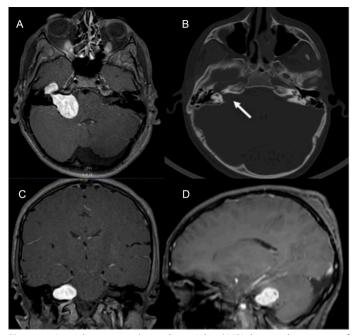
A: axial contrast-enhanced 1-weighted MRI shows enhancement of the right side mass. B: CT scan showing the tumor erosion of the right internal acoustic canal (white arrow). C and D: Coronal and sagittal MRI showing the mass effect of the tumor compression and dislocating the brainstem. CT, computed tomography; MRI, magnetic resonance imaging.
